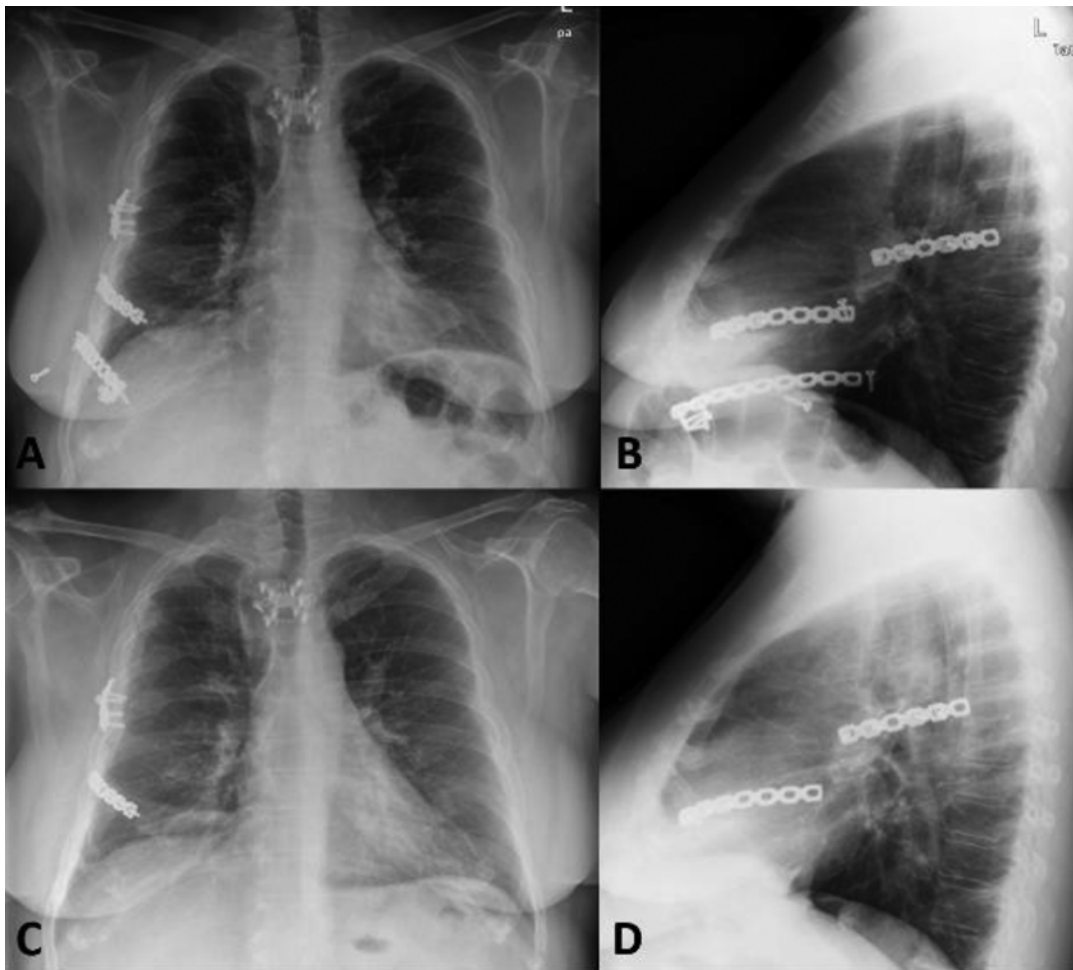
(a and b) PA and lateral chest radiographs 6 months postoperative showing fixation of multiple right-sided rib fractures and sternal fracture in a 63-year-old female patient with osteopenic bone. There are multiple loose screws in the muscles outside of the right hemithorax. The patient was complaining of persistent chest wall
